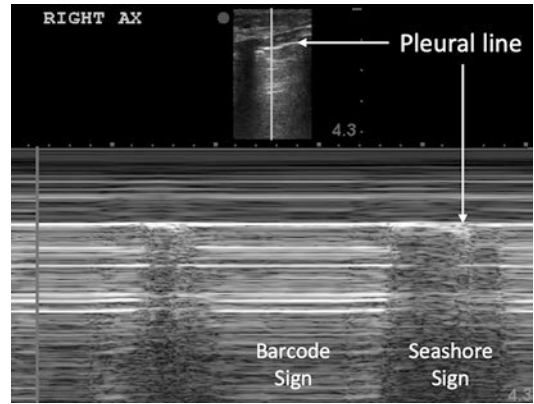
Linear probe M-mode ultrasound image at the site of a lung point, which is very specific sign for pneumothorax in the area under the ultrasound probe. In this image, there is intermittent “Seashore sign” and “Barcode sign” as the lung point comes in and out of the plane of the M-mode
